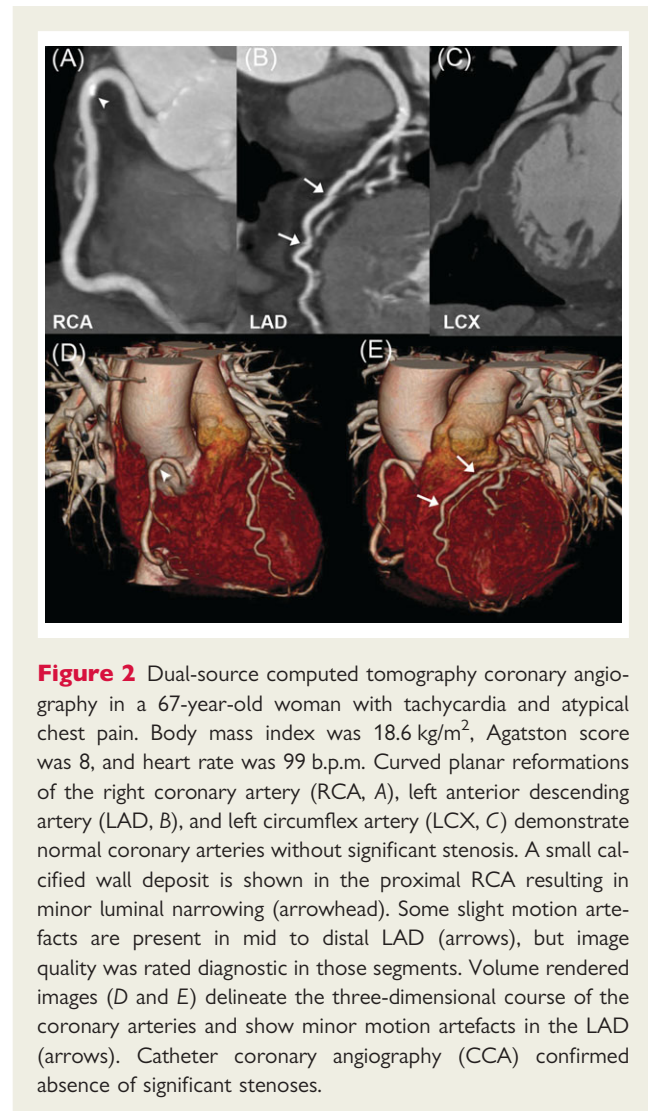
Dual-source computed tomography coronary angiography in a 67-year-old woman with tachycardia and atypical chest pain. Body mass index was 18.6 kg/m², Agatston score was 8, and heart rate was 99 b.p.m. Curved planar reformations of the right coronary artery (RCA, A), left anterior descending artery (LAD, B), and left circumflex artery (LCX, C) demonstrate normal coronary arteries without significant stenosis. A small calcified wall deposit is shown in the proximal RCA resulting in minor luminal narrowing (arrowhead). Some slight motion artefacts are present in mid to distal LAD (arrows), but image quality was rated diagnostic in those segments. Volume rendered images (D and E) delineate the three-dimensional course of the coronary arteries and show minor motion artefacts in the LAD (arrows). Catheter coronary angiography (CCA) confirmed absence of significant stenoses.
